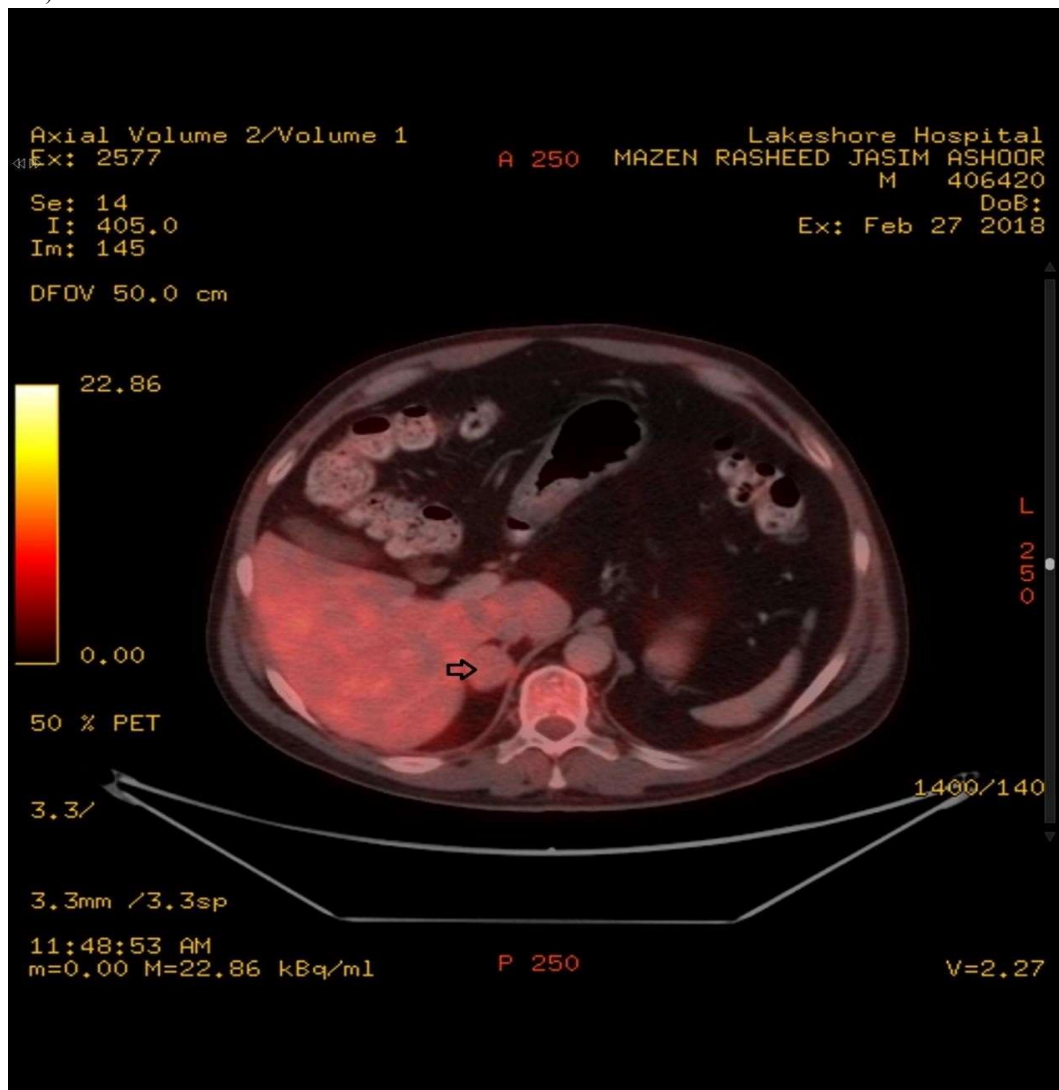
Whole body PET scan (vertex to mid-thigh) with contrast (oral and intravenous) enhanced CT was performed using a dedicated Discovery IQ PET 16 slice CT scanner 60 minutes after i.v. injection of 7 mCi of F-FDG. The blood glucose level was 115 mg/dl before the injection. The standardized uptake value (SUV) was calculated based in body weight and expressed in g/ml. There is an FDG negative well defined mildly enhancing soft tissue nodule measuring 27 x 23mm in the medial limb of right adrenal gland (arrow).
